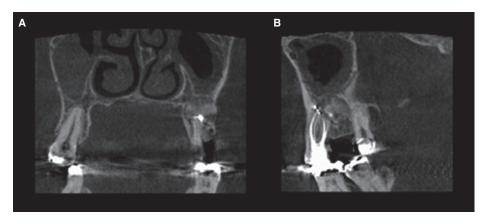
Subsequent CBCT of lesion showing progression in size, and development of radiopaque characteristic of lesion. Date of exposure: 24 October 2016. (A) coronal view; (B) sagittal view.
